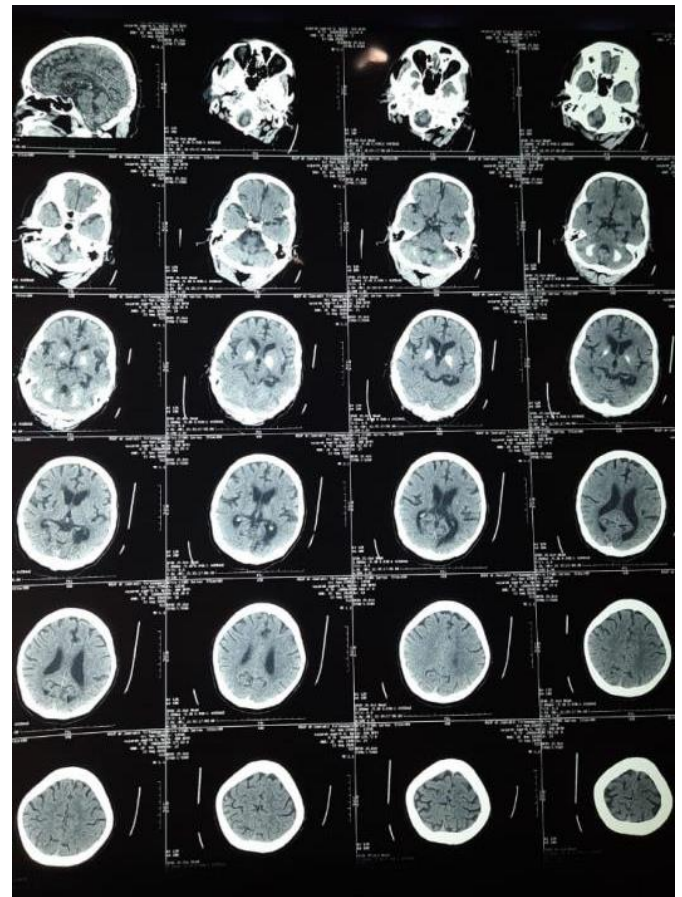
CT scan examination showed lacunar right basal ganglia infarction with prominent calcification of bilateral basal ganglia and cerebellum nuclei dentata
